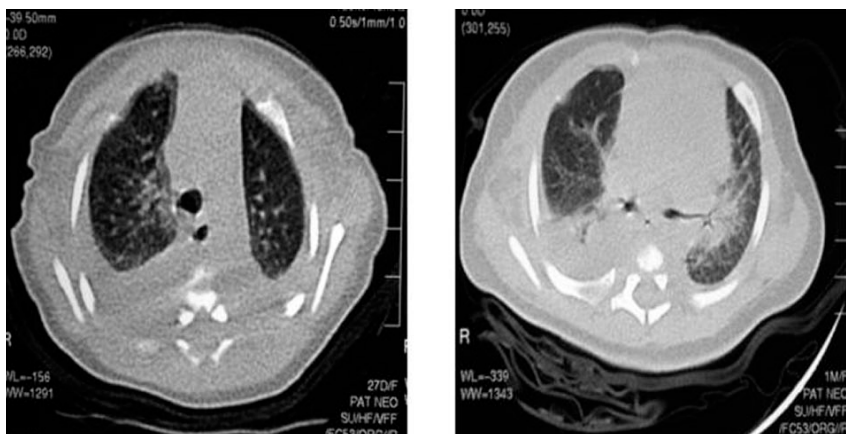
Congenital Pulmonary Lymphangiectasia. High-resolution CT images (2.0 mm thick sections at 10-mm intervals) demonstrate thickening of the interlobular septa and pleural effusion. This image is of a female patient, who presented with severe respiratory distress at birth requiring artificial ventilation and bilateral pleural drainage. Generalized lymphedema was evident, especially in the lower right leg and foot, and in the genitalia. Intestinal lymphangiectasia was suspected. No pulmonary biopsy was performed, however lymphoscintigraphy showed abnormal drainage of the lower limbs (right more than left), and demonstrated back-flow within the thoracic duct. The CT picture, together with clinical evidence and the lymphoscintigraphic study, strongly suggests a diagnosis of pulmonary lymphangiectasia.
